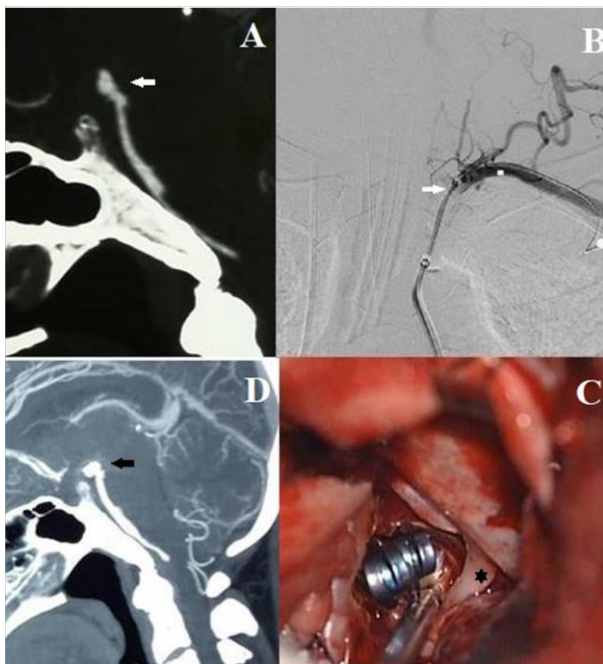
clockwise - CT angiography mid sagittal image (A)shows basilar top aneurysm(white arrow); left subclavian
